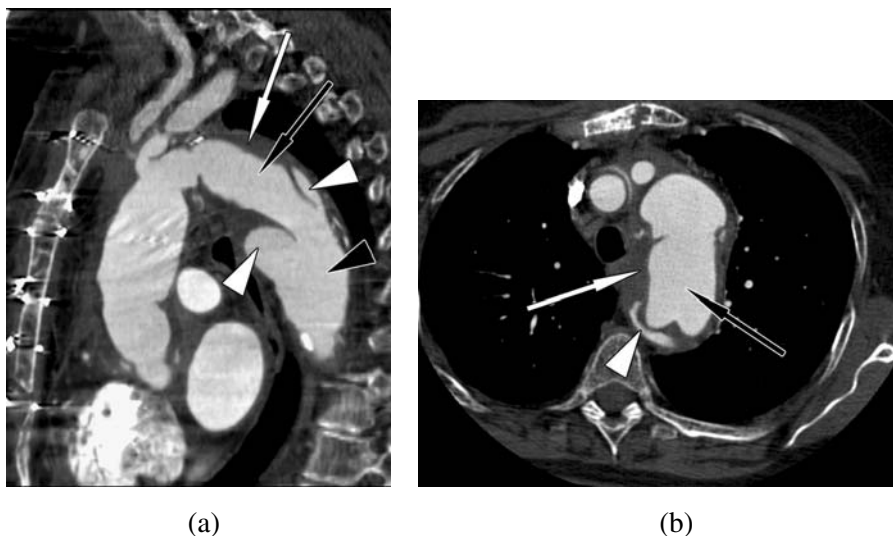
Multiplanar reformatted contrast-enhanced CT images after replacement of the ascending thoracic aorta and aortic arch with a graft that extends into the descending thoracic aorta using elephant trunk technique: (a) sagittal oblique reformatted image; (b) axial reformatted image at the level of the graft of the aortic arch and proximal descending thoracic aorta. The graft is indicated by the thin black arrow. There is a partially thrombosed aneurysm of the proximal descending thoracic aorta surrounding the graft (thin white arrow). There is retrograde flow of contrast into the aneurysm (white arrowhead); the descending thoracic aorta distal to the graft is indicated by the black arrowhead. The appearance is entirely due to the presence of the graft within the aneurysm of the descending thoracic aorta, and there is no dissection.
